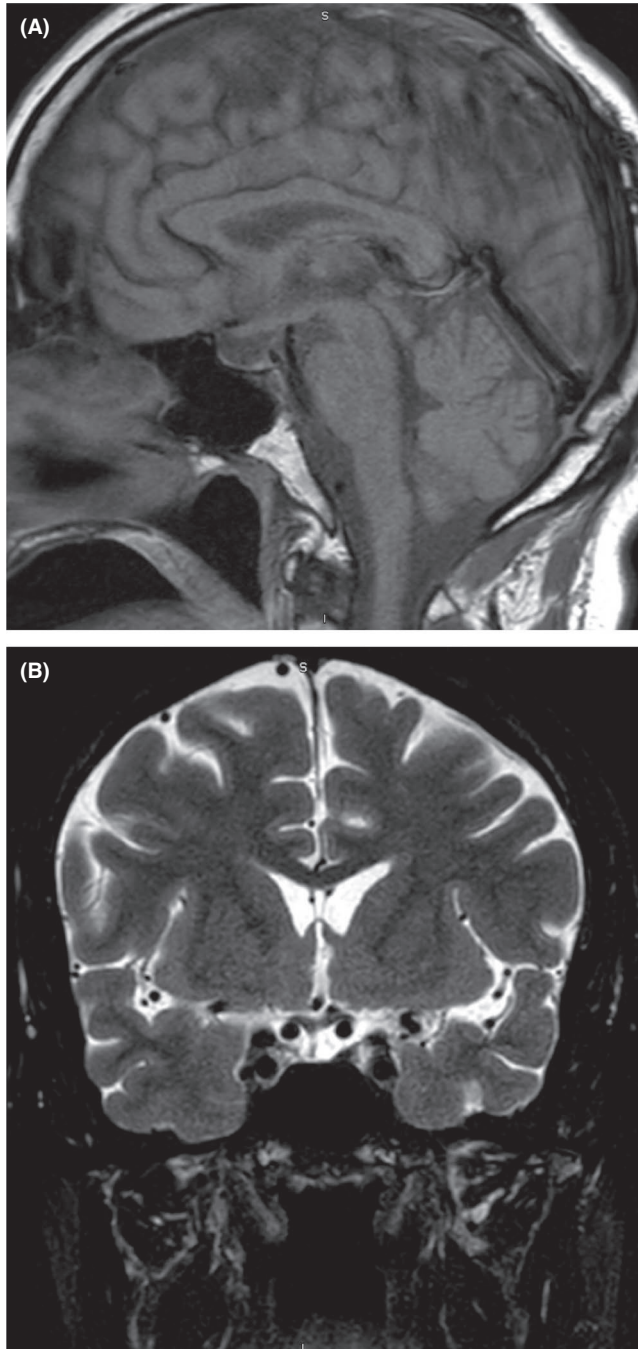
Sagittal T1 and coronal T2 sections of magnetic resonance imaging show marked thinning of the anterior lobe of the pituitary gland, about 1–2 mm in height in shallow sella turcica, and no evidence of suprasellar or parasellar mass
